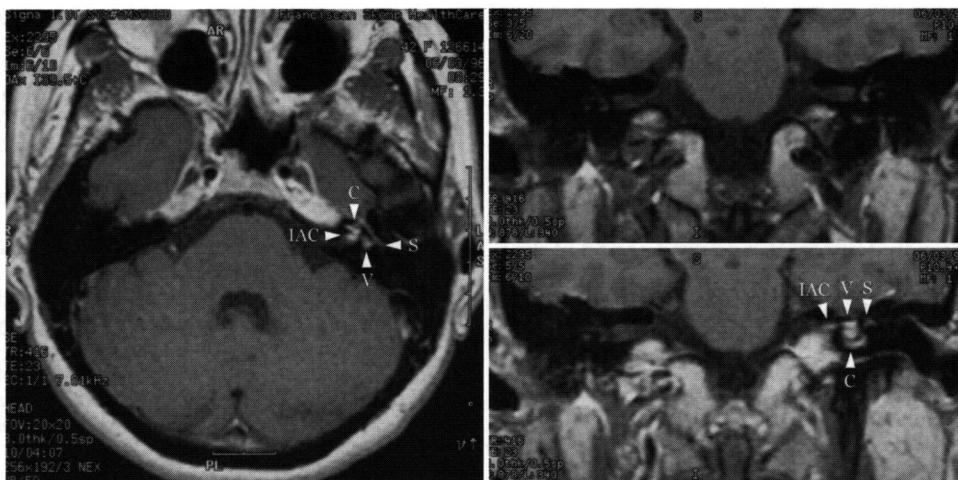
Magnetic resonance images obtained 6 years before diagnosis. Results of this study were also reported to be normal, although axial postcontrast (*left*) and coronal pre- (*upper right*) and postcontrast (*lower right*) images demonstrate the left-sided lesion involving the labyrinthine vestibule (V) and semicircular canals (S) in addition to the basal turn of the cochlea and distal IAC.
